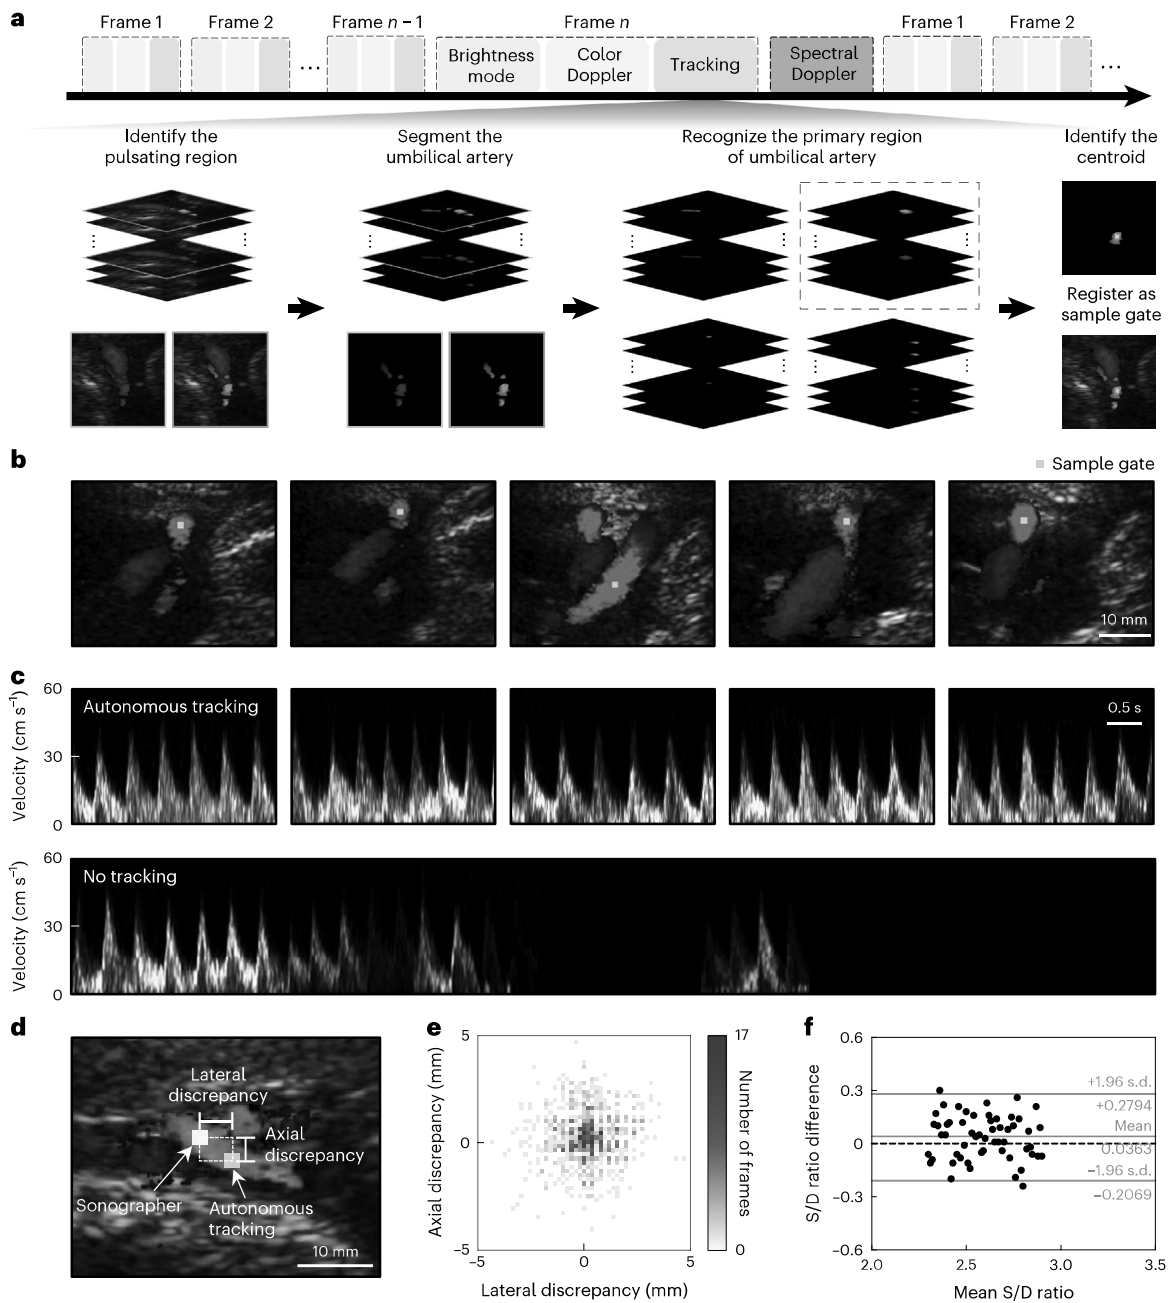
Autonomous vessel tracking by image segmentation. a, Beam-forming sequence and working principle of the image segmentation-based vessel-tracking algorithm. Top, the tracking algorithm operates between the duplex imaging and spectral Doppler. Bottom, the algorithm identifies the pulsating regions in consecutive frames, segments the umbilical artery, recognizes the primary region and registers the spatial centroid as the sample gate. Images outlined in green and orange represent the end diastole and peak systole, respectively. In these two images, the blue regions show similar intensities, indicating the non-pulsatile umbilical vein, whereas the red regions show intensity differences, indicating the pulsatile umbilical artery. Among the four segmented areas, the primary region is defined as the largest segmented area (denoted with the black dashed box). b, Tracking a moving umbilical artery and registering a sample gate using the UPatch with the autonomous algorithm.
